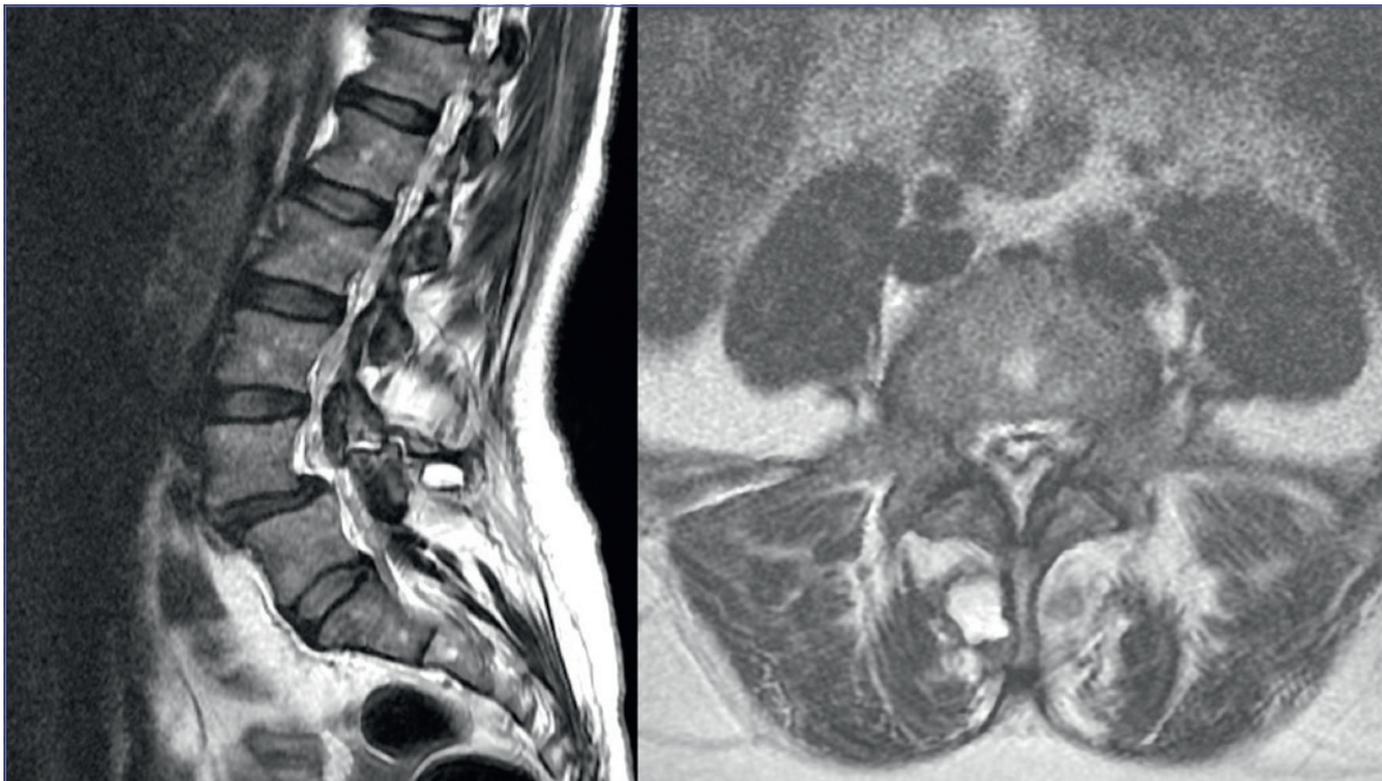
Sagittal and axial T2 weight MRI showing L4 isthmic spondylolisthesis and pseudomeningocele at the right side of spinous process.
